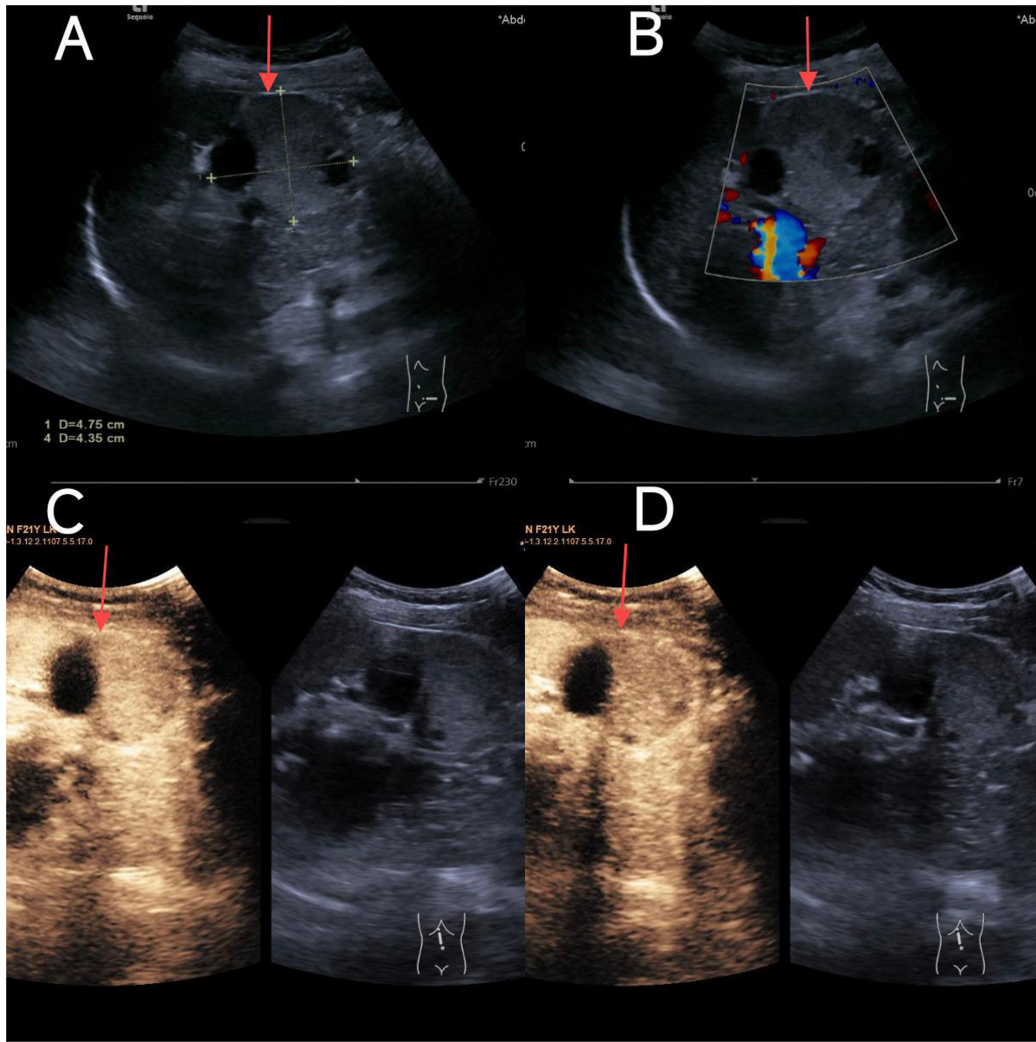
Ultrasonographic findings. (A) Conventional ultrasound examination identifying a cystic-solid lesion measuring ~48x44 mm located in the tail of the pancreas (arrow). (B) Color Doppler flow imaging revealing no detectable intratumoral blood flow (arrow). (C) The lesion demonstrates moderate enhancement, with clearly delineated non-enhancing regions during the arterial phase on contrast-enhanced ultrasound (arrow). (D) Enhanced ultrasound showing persistent low enhancement of the lesion in the venous phase (arrow).
